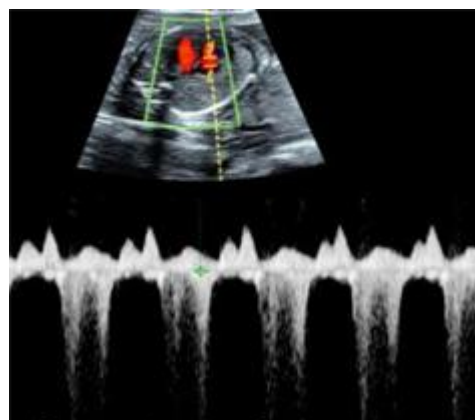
USG with Spectral Doppler of the regurgitant jet in mitral valve showing increased peak systolic velocity (~75 cm/sec).
